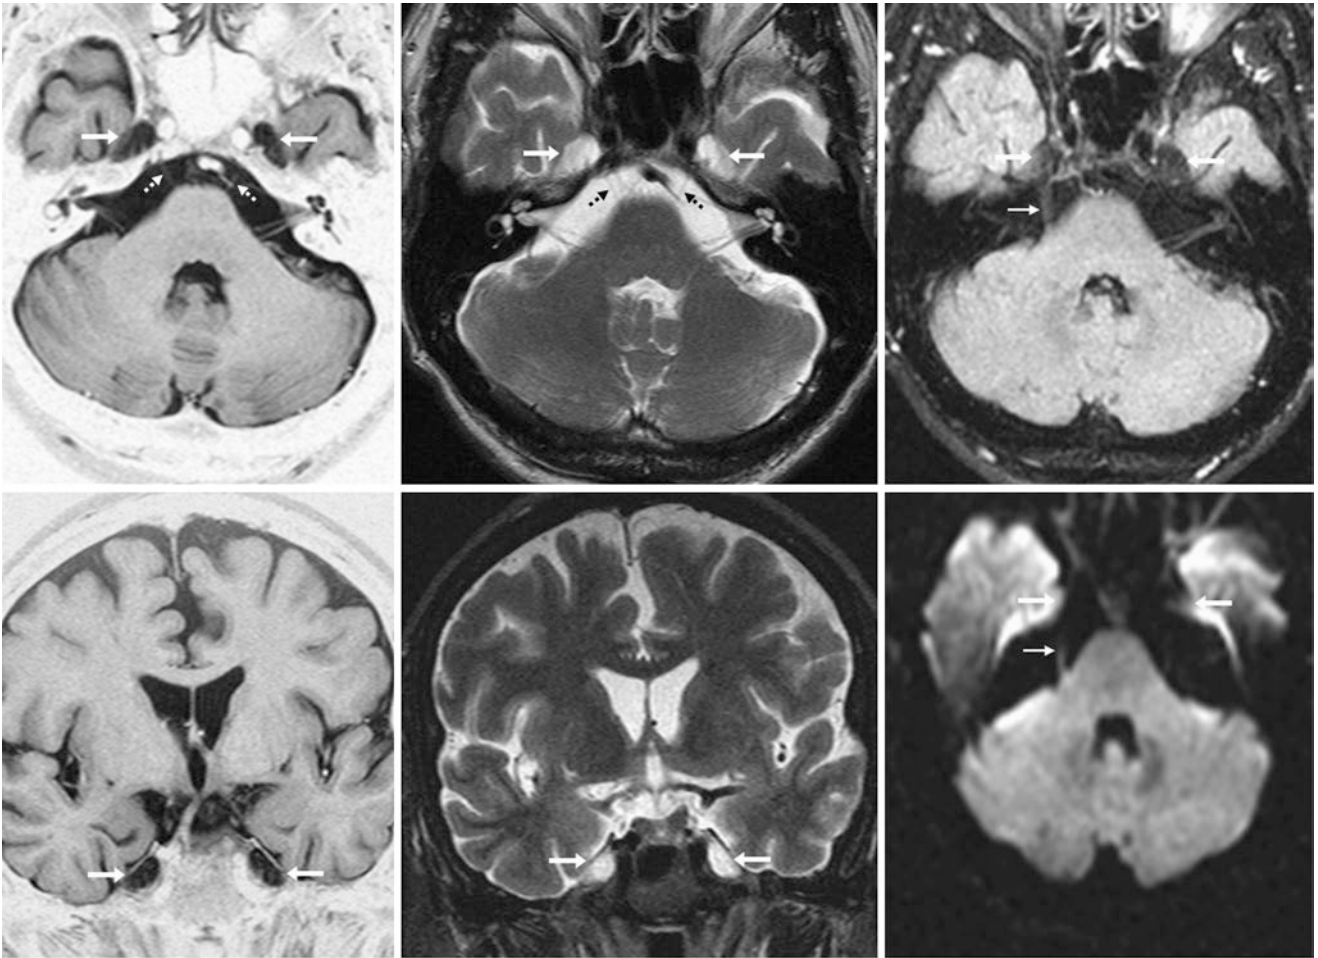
A 69-year-old patient with moderately prominent Meckel caves (*arrows*) bilaterally on a 1.5 T MRI with axial T1WI-IR (*top left*), T2WI (*top middle*), FLAIR (*top right*), coronal T1WI-IR (*bottom left*), T2WI (*bottom middle*), and axial DWI (*bottom right*). Note the cisternal courses of the right cranial nerve V (*thin arrows*) and the bilateral
